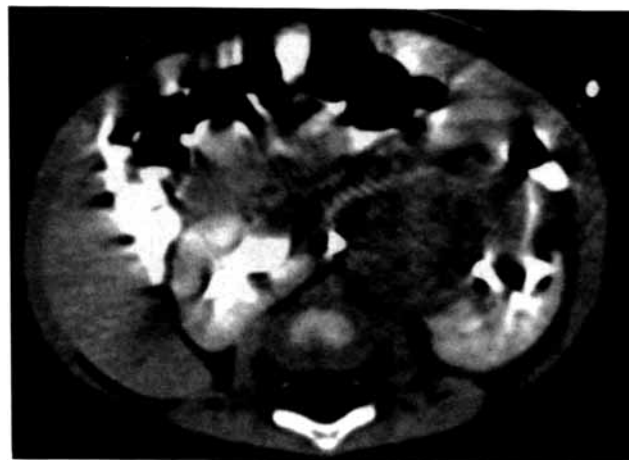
Postoperatively CT reveals tumor in isthmus of horseshoe kidney and drain in cystic part of tumor.
